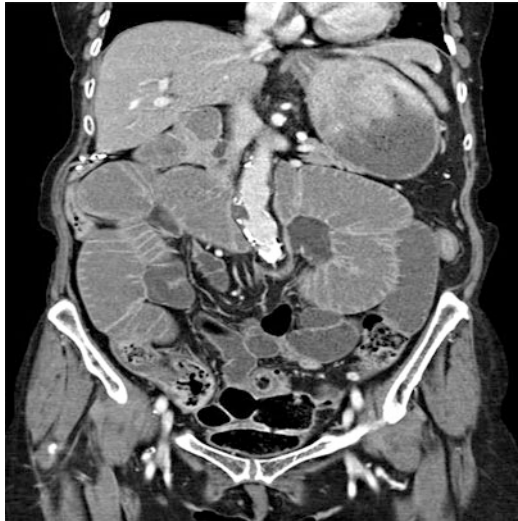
CT scan with extensive small bowel dilatation and fluid filled consistently with a distal small bowel obstruction. © Dale Dangleben, MD
